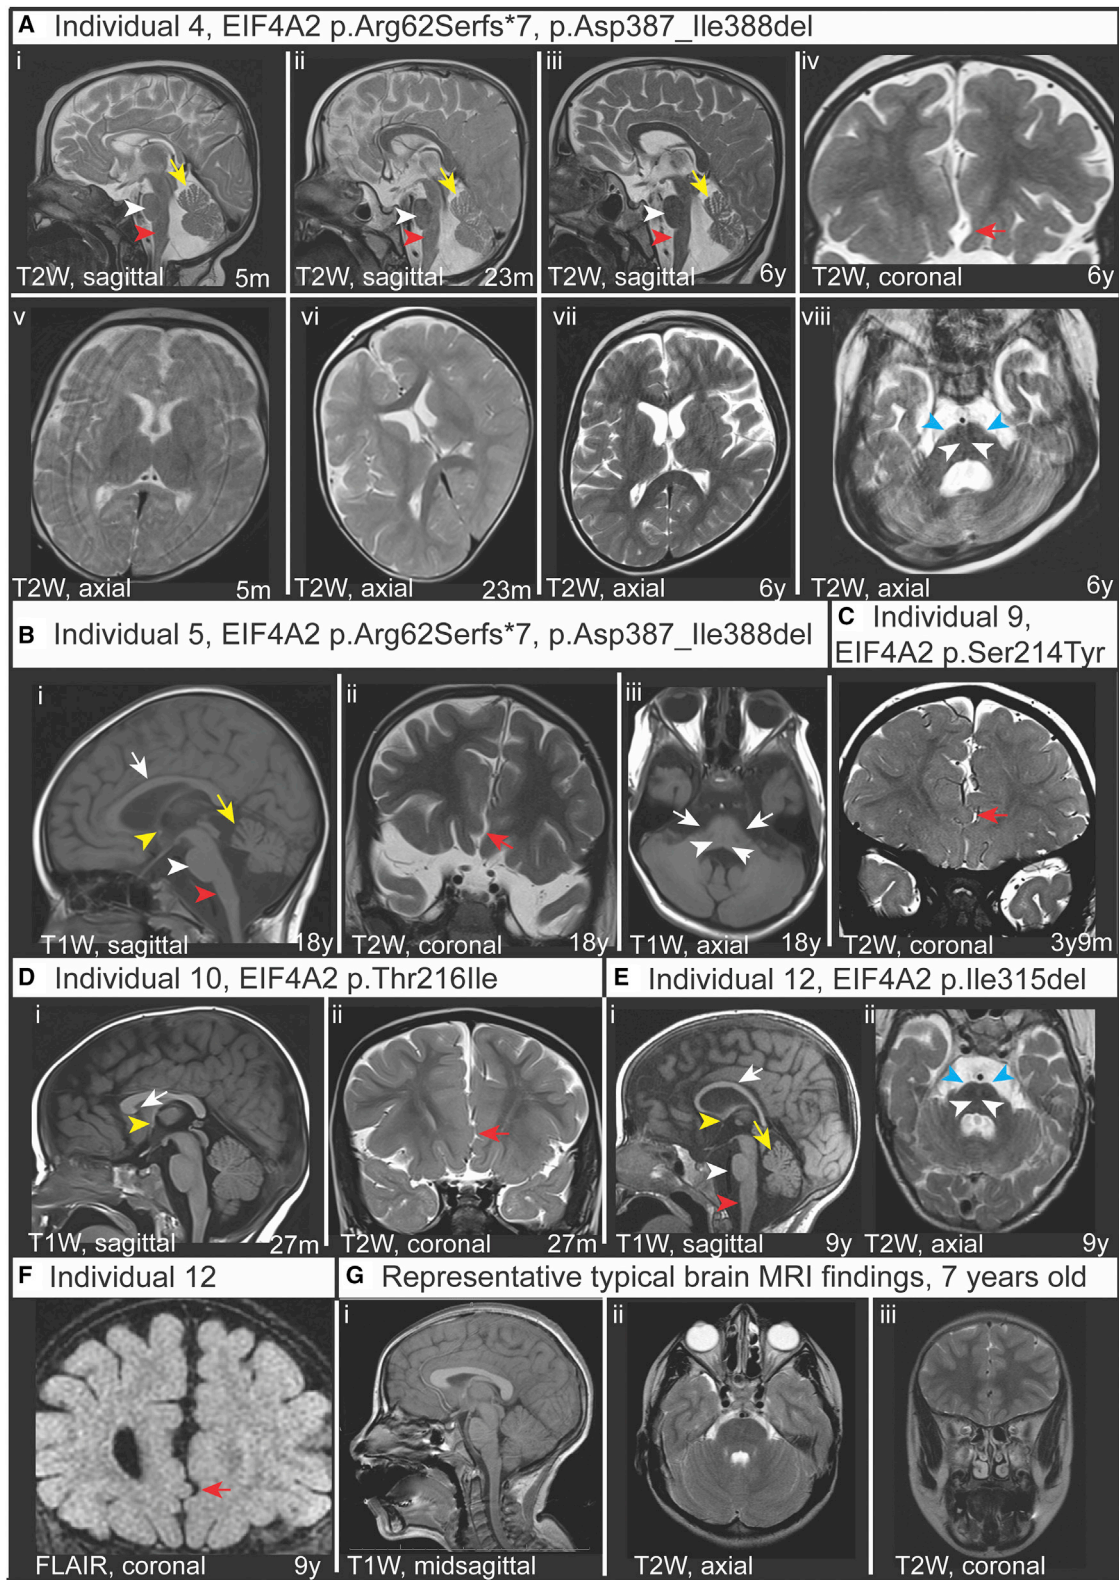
Neuroanatomical MRI findings in individuals with *EIF4A2* variants
